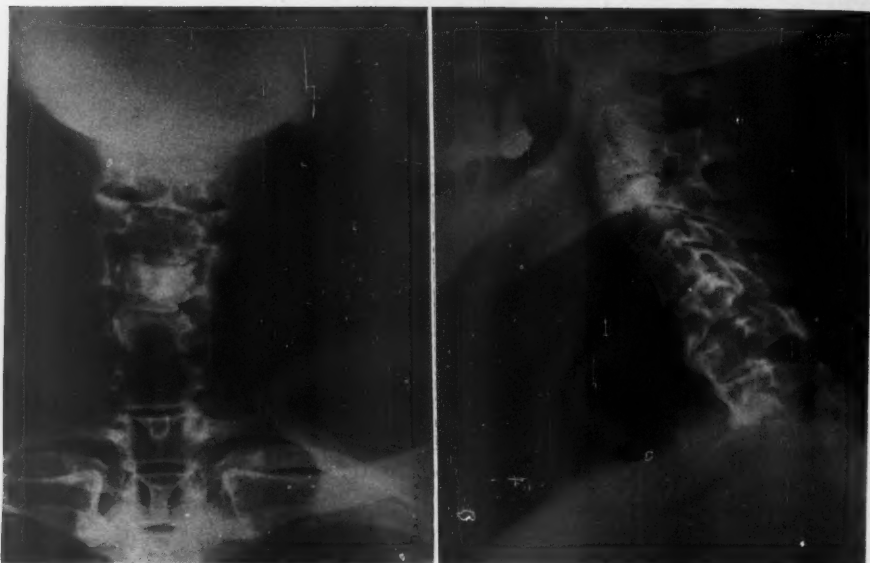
X-rays, 14 months following injury, showing essentially the same degree of osteoarthritis
